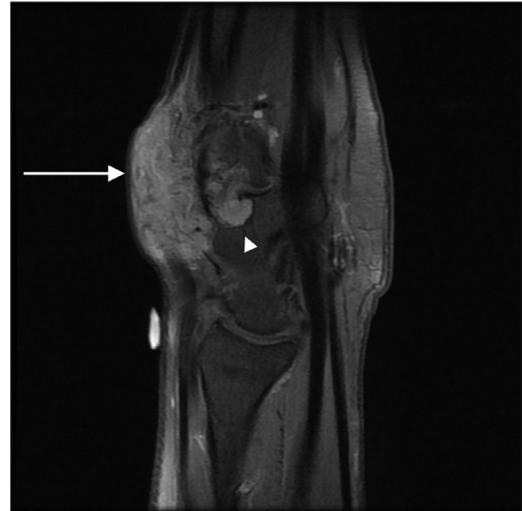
Sagittal T1-weighted fat-saturated postcontrast MR image of the wrist showing enhancing soft tissue mass (white arrow) of the dorsal aspect with small areas of involvement (white arrowhead) of the hamate and base of the fourth metacarpal.
